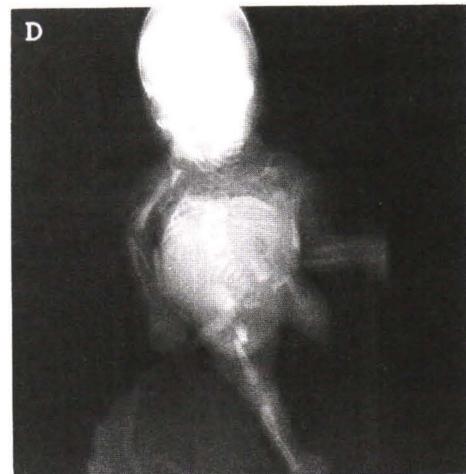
Postnatal X-ray (fracture of right femur occurred during delivery).
